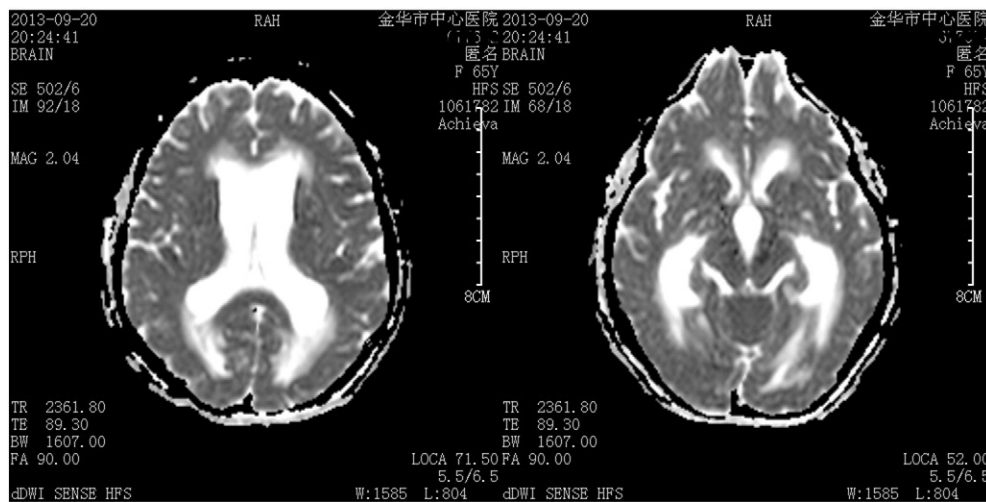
Cranial MRI showing enlarged lateral ventricles and third ventricle, indicating hydrocephalus.
